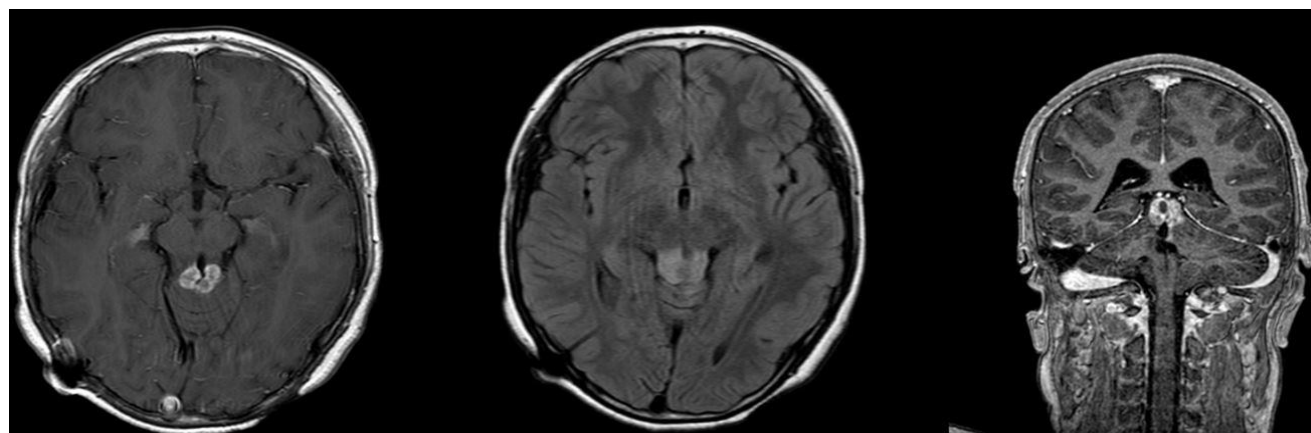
Magnetic resonance imaging of the 11-year-old boy with anaplastic ependymoma in the tectal region.
